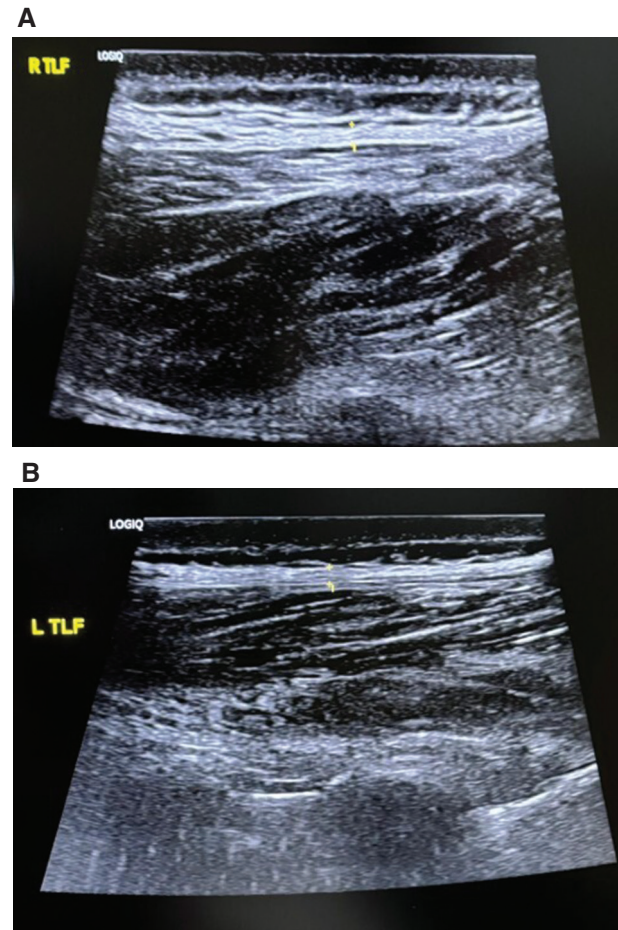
Thickness of the TLF in ultrasound images: (A) Right TLF. (B) Left TLF. TLF = thoracolumbar fascia.
